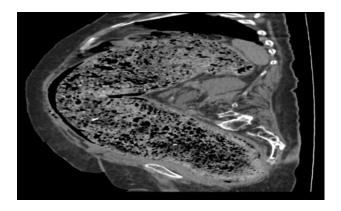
Sagittal view of the abdominal CT of fecal impaction.
